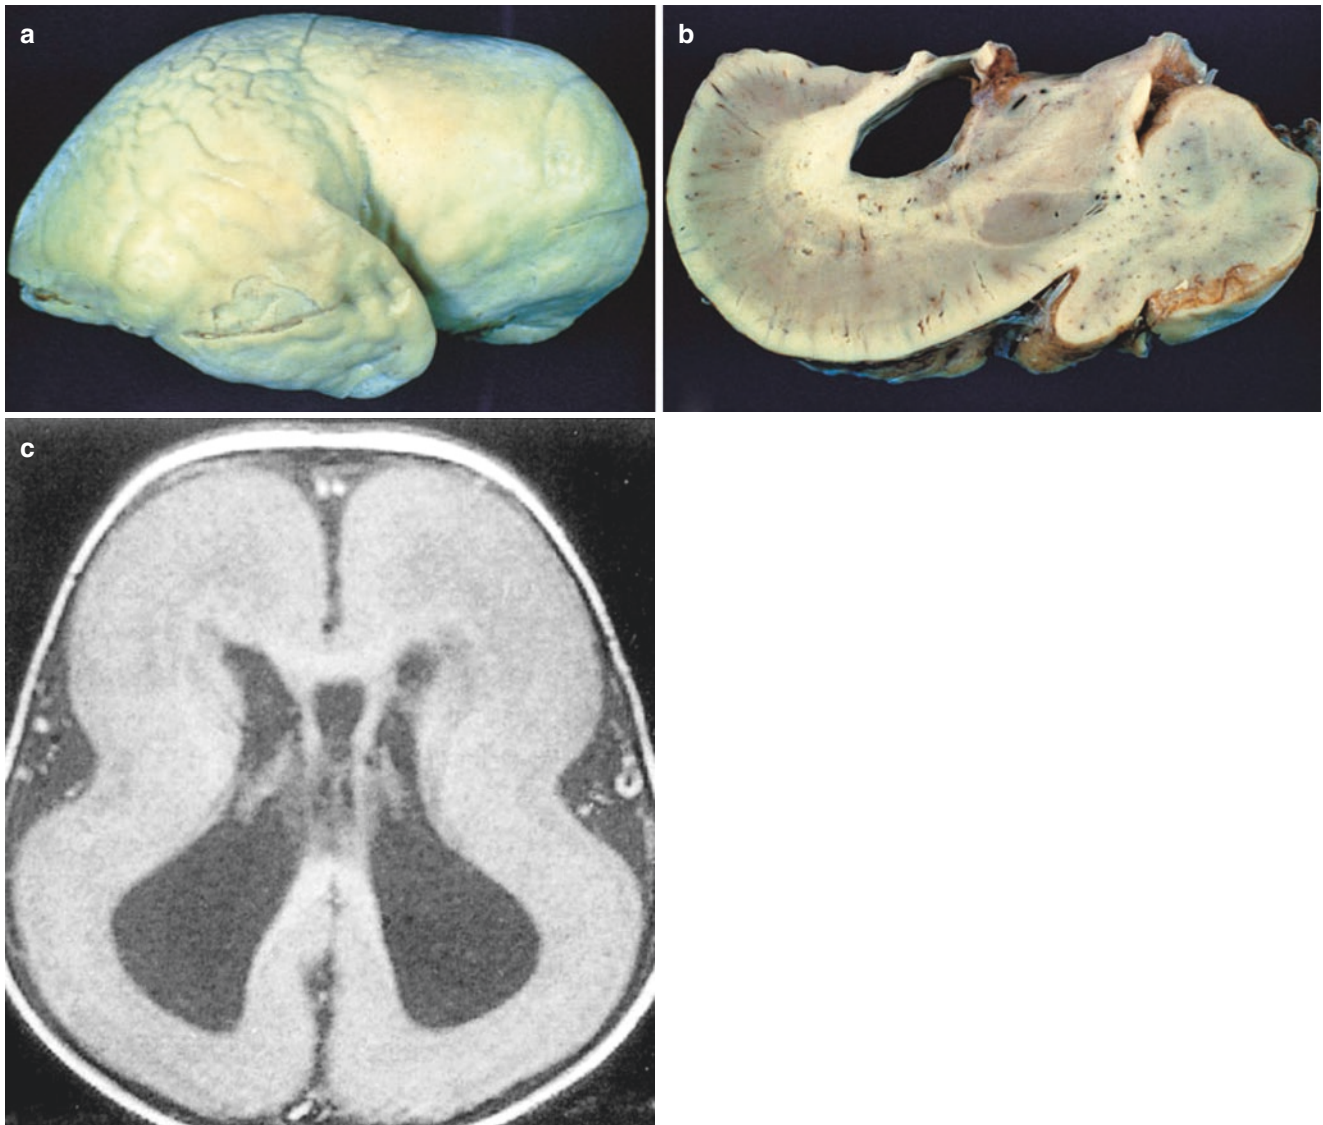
Thickened simple cortex showing type I lissencephaly (classic lissencephaly). (a and b) On gross inspection, much of the cortical surface is smooth and agyric. (c) T1-weighted MRI of type I lissencephaly
